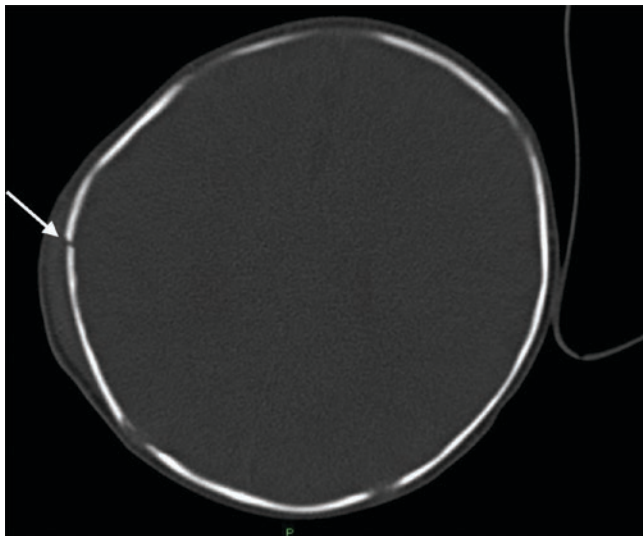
Axial CT image demonstrates an undisplaced right parietal bone fracture (*arrow*) and adjacent scalp swelling
